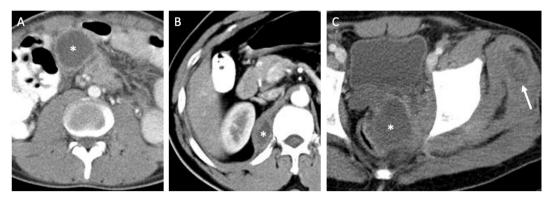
Tuberculous abscess in multiple different patients. Contrast-enhanced CT demonstrates a peripherally enhancing A) mesenteric, B) left diaphragmatic crus, C) pericolic abscess (asterisk). A small left gluteal abscess is also seen (arrow).
